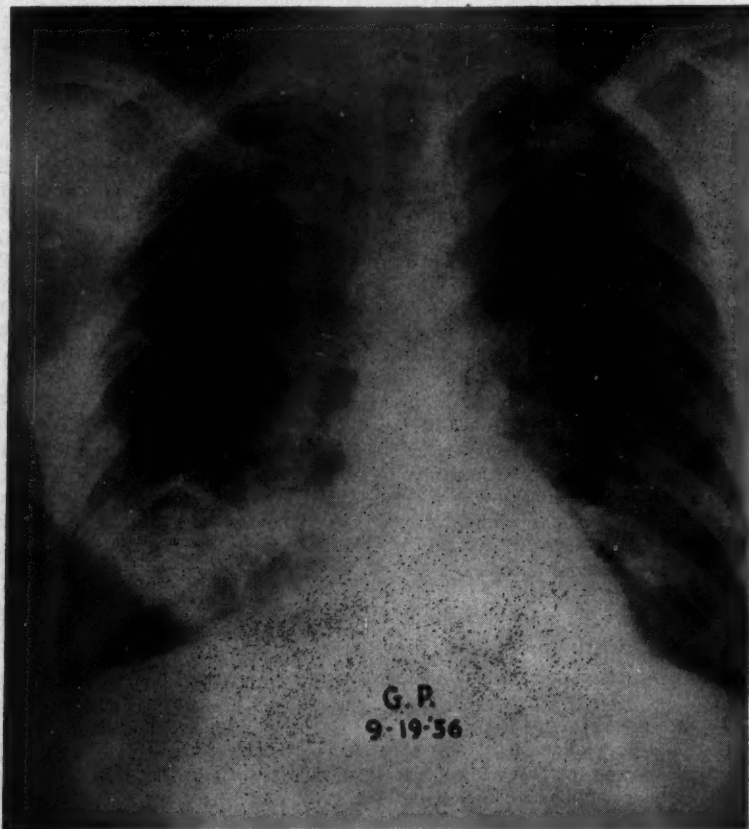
Chest x-ray of case 8 during the acute illness, showing extensive bilateral densities.
